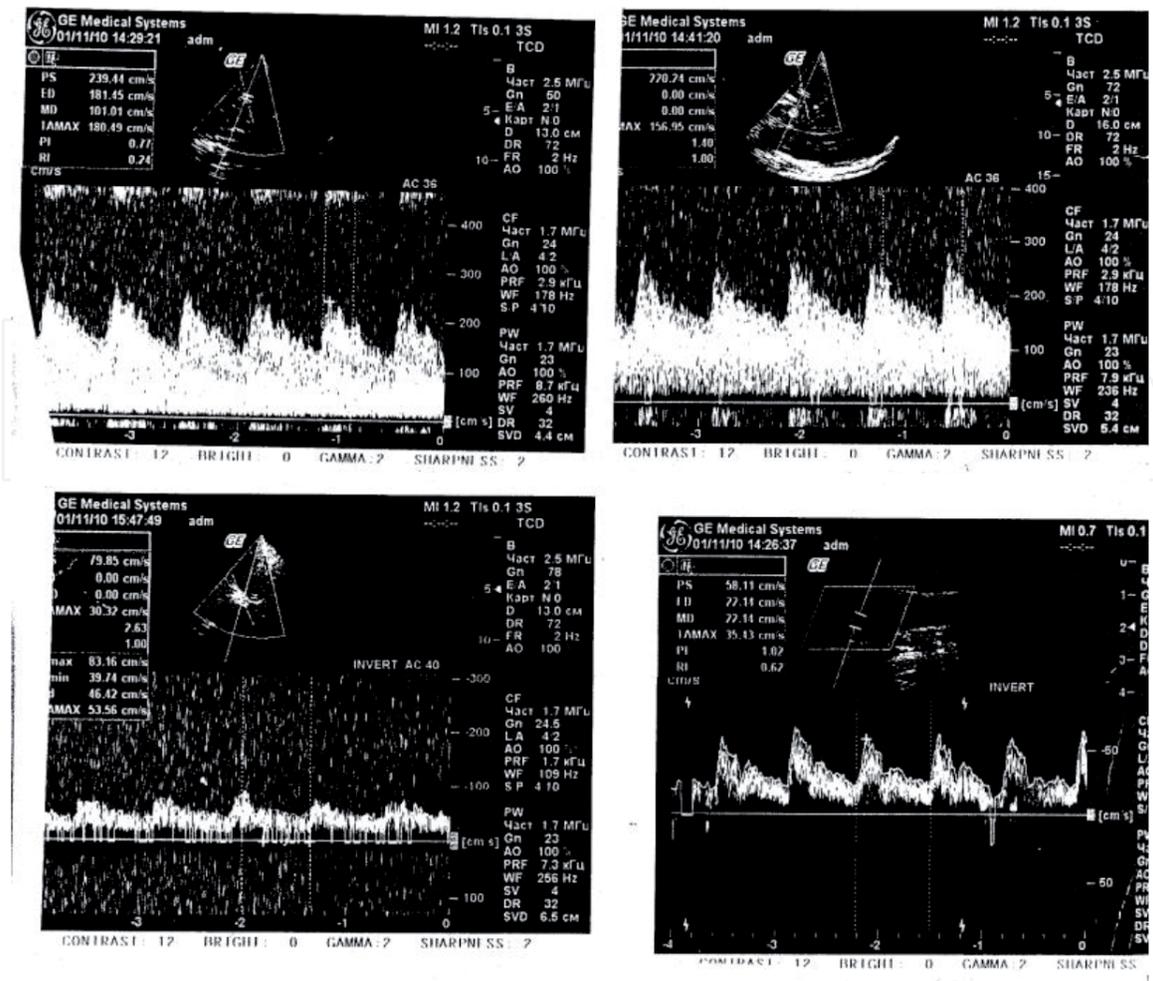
Cerebral vasospasm of the III st. in both MCA (D < S) in patient M. on the 16th day from a rupture of the ACA aneurysm. Doppler study data.
